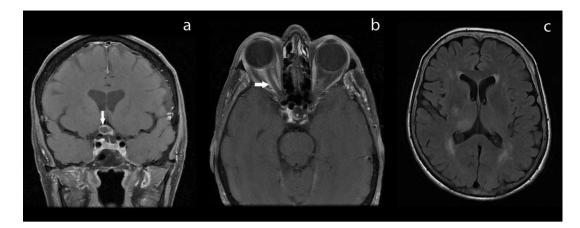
(a) Coronal T1-weighted contrast-enhanced MRI showing ring enhancement of the chiasm (arrow); (b) axial T1-weighted contrast-enhanced MRI showing enlargement and enhancement of the right optic nerve (arrow); (c) axial fluid attenuated inversion recovery (FLAIR) MRI showing high signal in the periventricular deep white matter, multiple foci involving the parieto-occipital and fronto-parietal regions.
